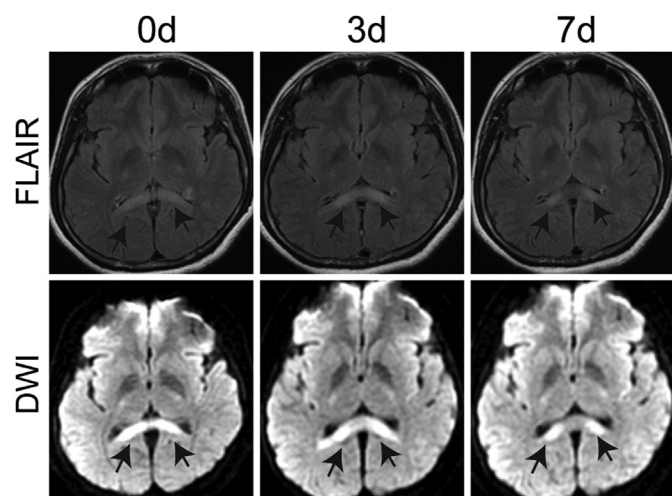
MR imaging of patient 1. On admission, the corpus callosum could be seen high FLAIR abnormal signal with unclear margins, lesion was high signal on DWI. After 3 days of treatment, the corpus callosum could be seen high FLAIR abnormal signal with unclear margins, the lesion was high signal on DWI. After 7 days of treatment, the lesions had basically recovered, as seen on DWI.
